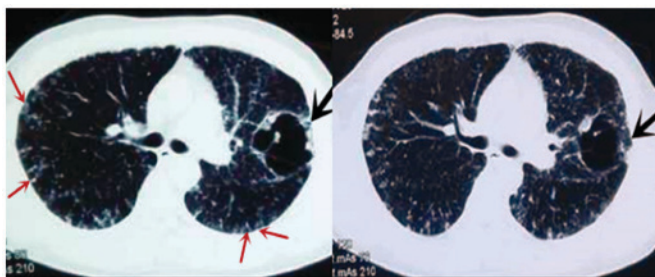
A large, abnormal cystic lesion in the left lung of a 33-year-old male (black arrow) and multiple cystic lesions (red arrow) in the two lungs on computed tomography images.
